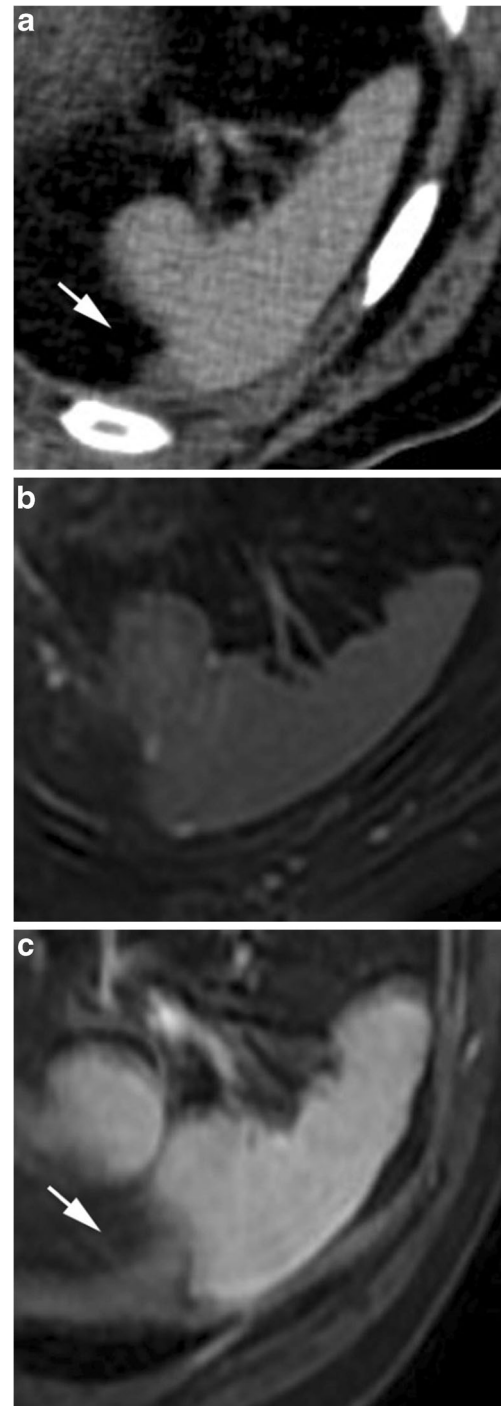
A 71-year-old male patient with blunt abdominal trauma after fall. a Transverse portal-venous phase CT were interpreted as showing perisplenic fluid (*arrow*). b T2-weighted MR images at the same level demonstrate a normal configured spleen without a lesion or perisplenic fluid. c Contrast-enhanced T1-weighted MR images in the venous phase shows thickening of the diaphragm (*arrow*) mimicking perisplenic fluid at CT
